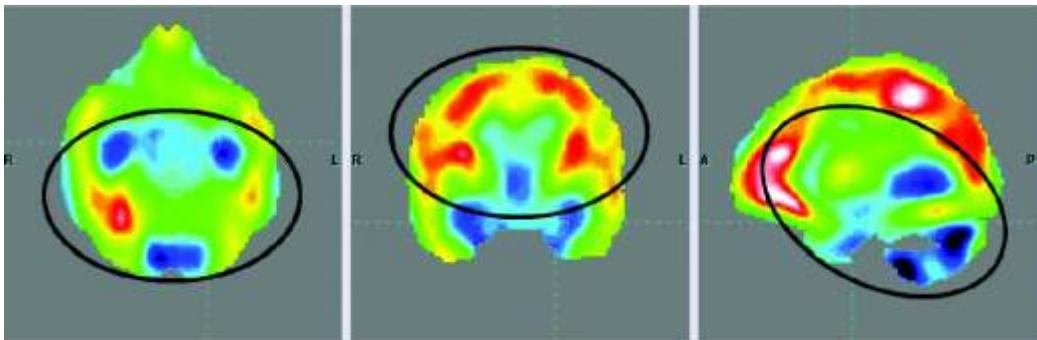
PET-CT scan 6 months after cellular transplantation showing increased metabolism in the regions of mesial temporal lobes, amygdala, hippocampus, and cerebellum bilaterally; indicated by reduction in the blue and black areas
